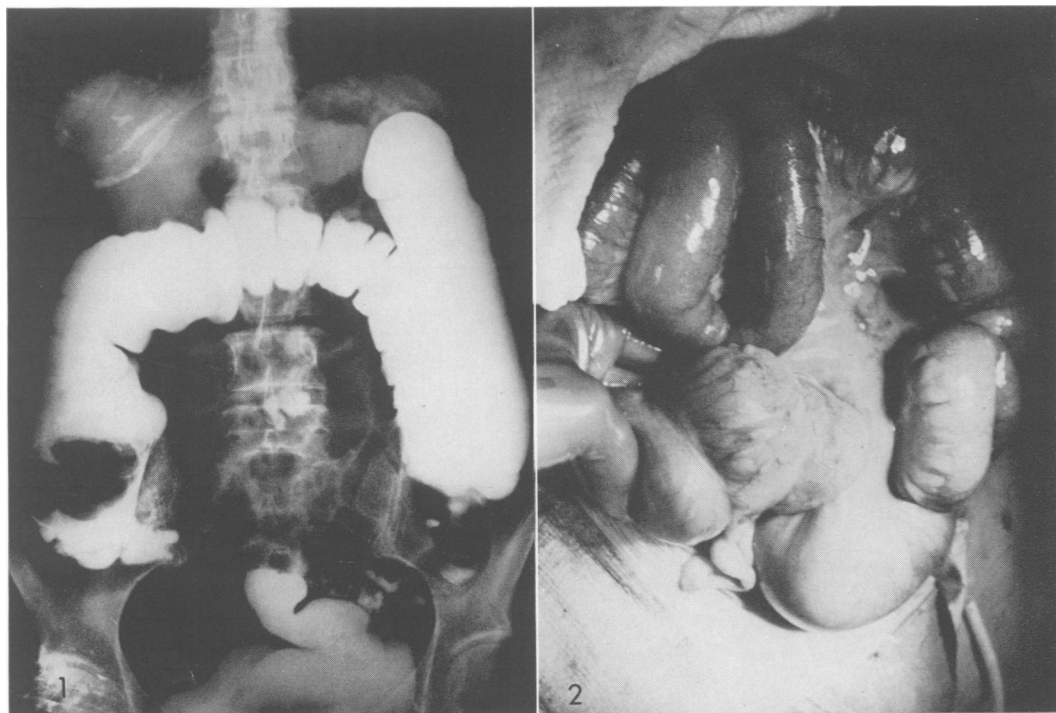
Barium enema x-ray shows a filling defect in the cecum representing an ileocolic intussusception. Intermittent symptoms of bowel obstruction and a normal barium enema x-ray 3 months previously helped make the diagnosis.
